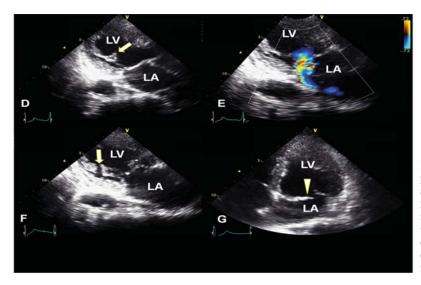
(D). Echocardiogram (parasternal long axis view) shows partially ruptured posteromedial papillary muscle. (LA: left atrium; LV: left ventricle). (E). Echocardiogram (apical 2-chamber view) shows posteriorly directed eccentric severe mitral regurgitant jet. (F) Echocardiogram (apical 2-chamber view) shows linear echo-lucency demonstrating transection of the muscular body of the posteromedial papillary muscle. (G) Echocardiogram (modified apical 4-chamber view) shows flail anterior mitral valve leaflet.
